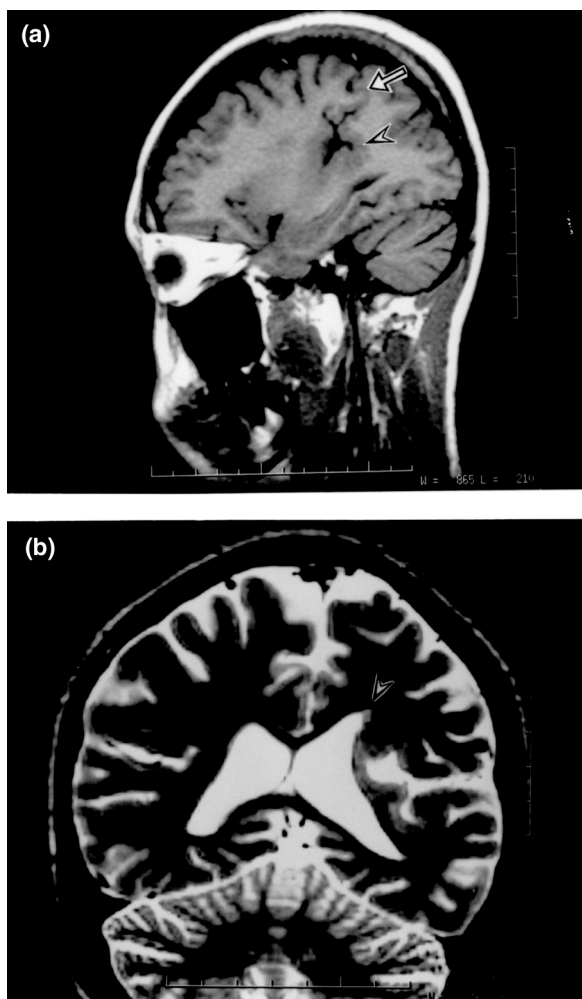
(a), Sagittal T1-weighted MRI demonstrating a cleft in the left temporo-parietal region (arrowhead), posterior to the central sulcus (arrow). (b), Coronal T2-weighted MRI demonstrating infolding heterotopic gray matters in the cleft which does not communicate with the lateral ventricle. Some heterotopic nodules were noted in the ventricular wall (arrowhead).
